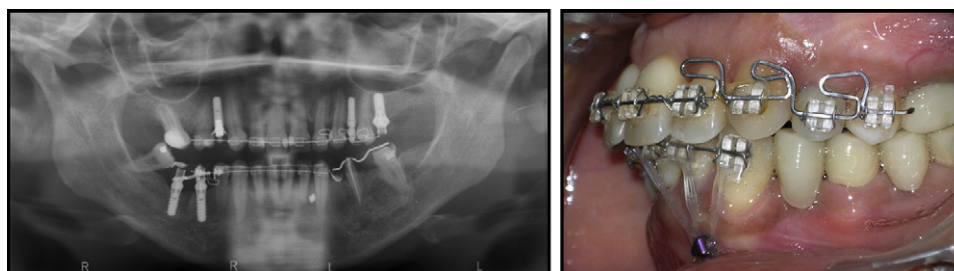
Panoramic x-ray and intraoral photos after the left-side maxillary and mandibular intrusion.
